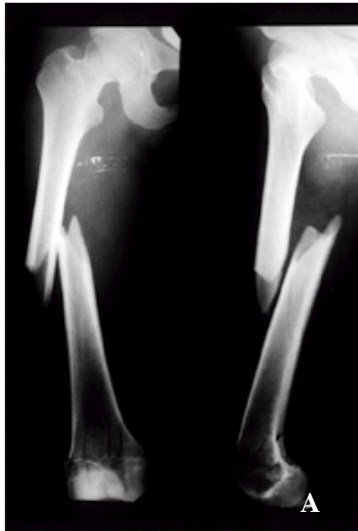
Initial X-Ray of twenty-four years old female showing the femoral shaft fracture and comminuted fracture of distal femur.
